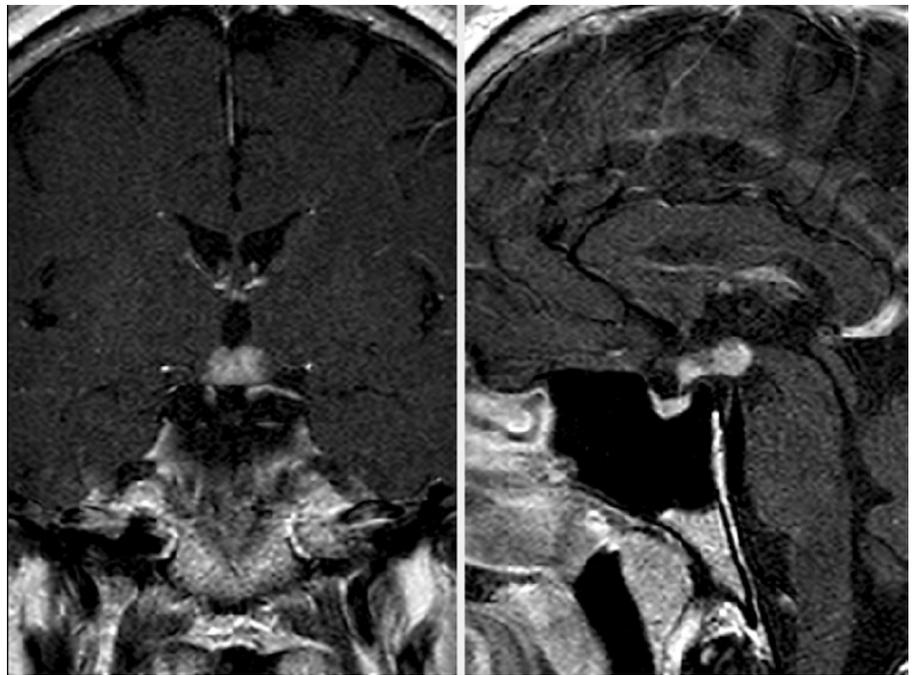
Langerhans cell histiocytosis, T1-W postgadolinium MRI.
